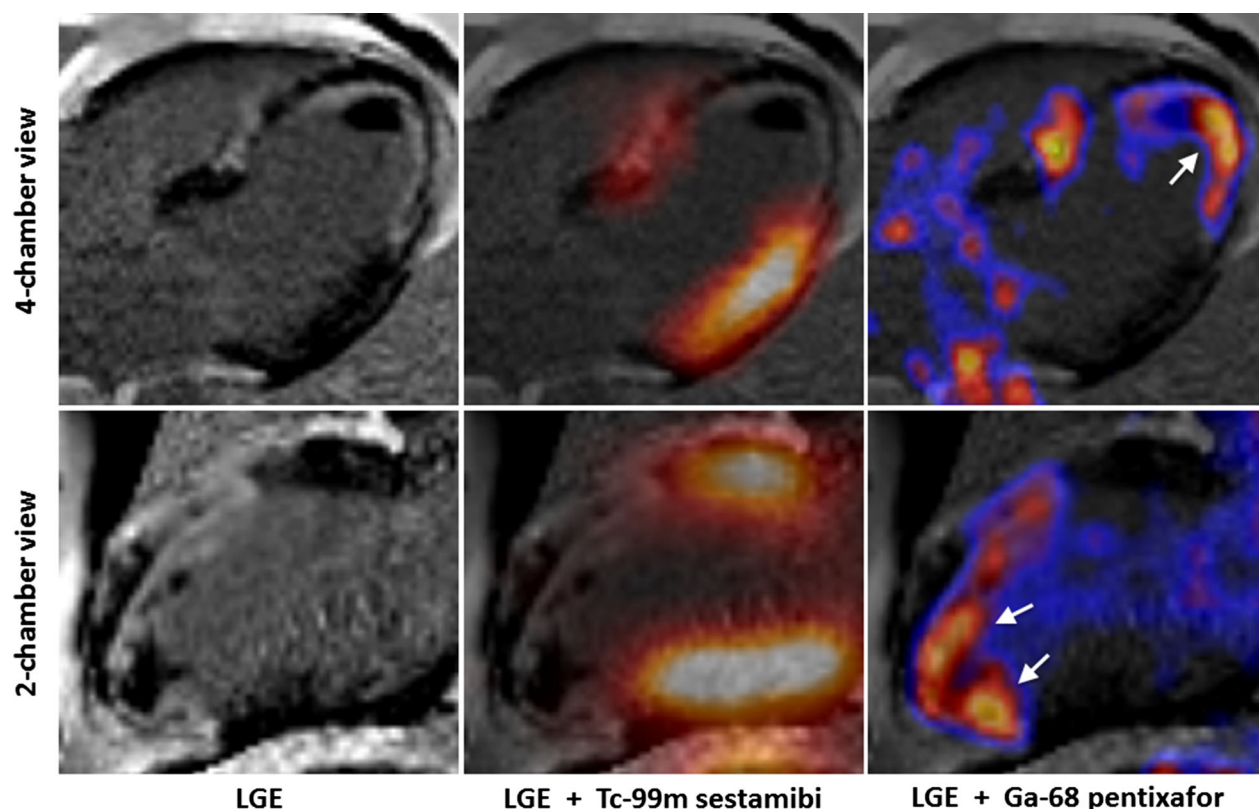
2- and 4-chamber views of the late gadolinium enhancement (LGE) MR images show transmural scar in the LAD territory. Furthermore, large areas of microvascular obstruction and a left ventricular thrombus can be observed (*left column*). Tc-99m sestamibi SPECT images demonstrate absent perfusion corresponding to the scar area on MR images (*middle column*). Ga-68 pentixafor PET images reveal markedly increased CXCR4 expression in the infarct area, indicating active inflammatory processes (*right column*).
